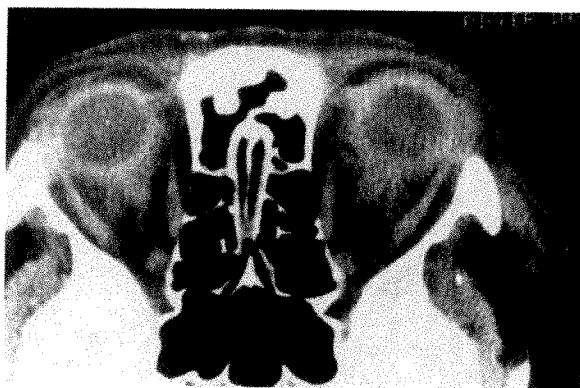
(Havunjian, Goldberg, and Hepler). Orbital computed tomographic scan showing posterior scleral thickening, anterior orbital inflammation, and enhancement of the muscle tendons and periocular soft tissues. Note that the sinuses are clear.
